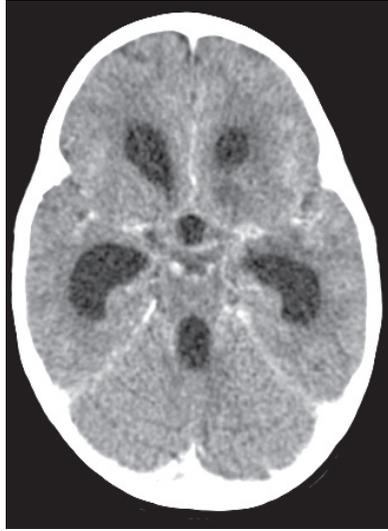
Contrasted computed tomography showing a combination of hydrocephalus, basal meningeal enhancement and infarction.
